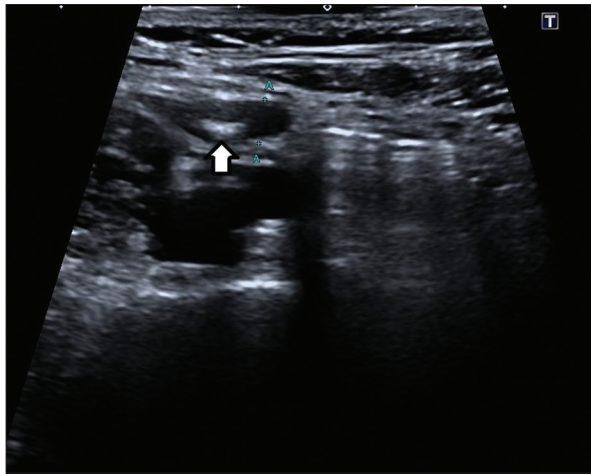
Presence of noncalcified fecolith (white arrow) within the appendiceal lumen. Noncalcified fecolith may be missed on computed tomography scan
